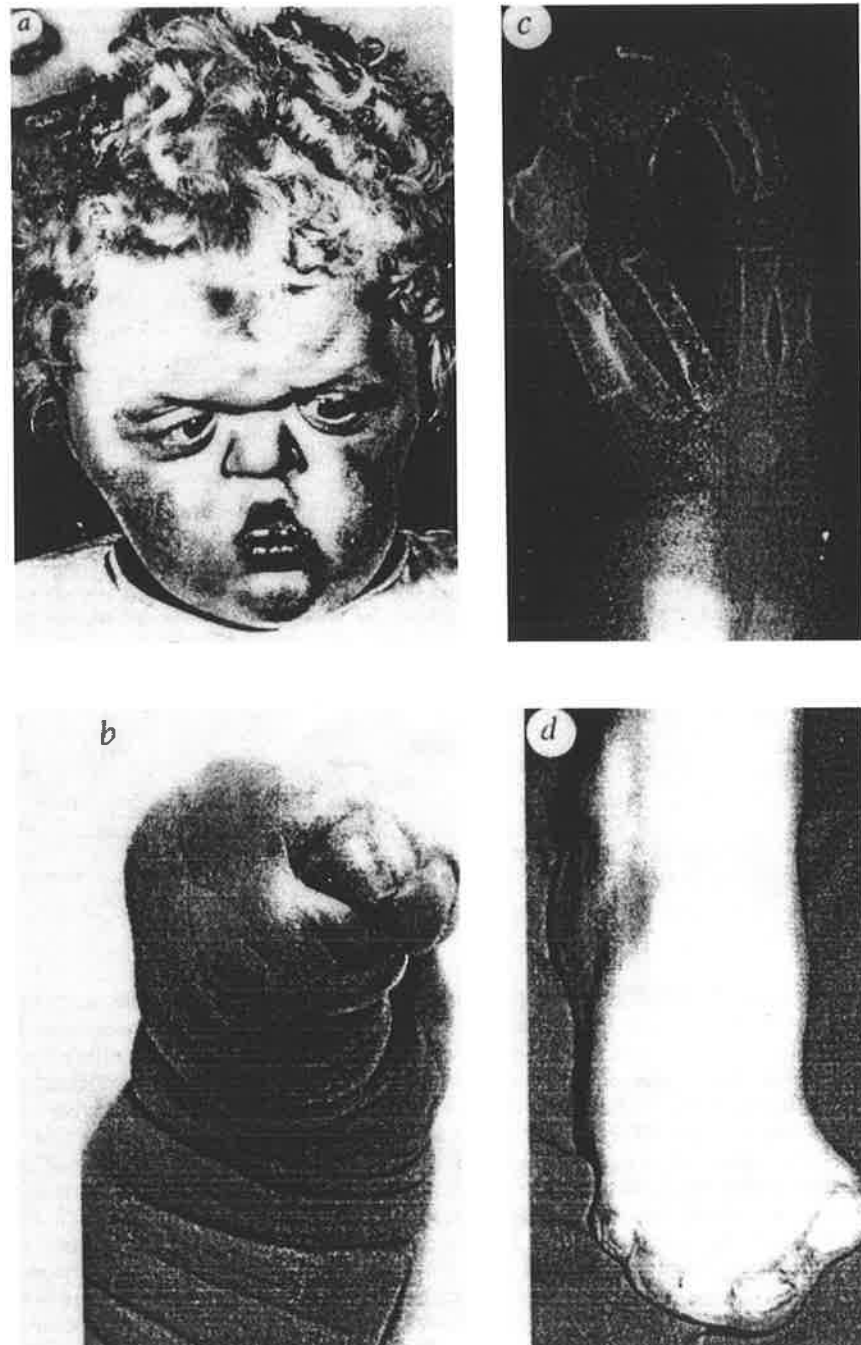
Clinical features of Apert syndrome. a. facial appearance; b. hand: severe syndactyly (type 3); c. radiograph of hand showing transverse phalangeal fusion; d. foot: severe syndactyly (type 3).
